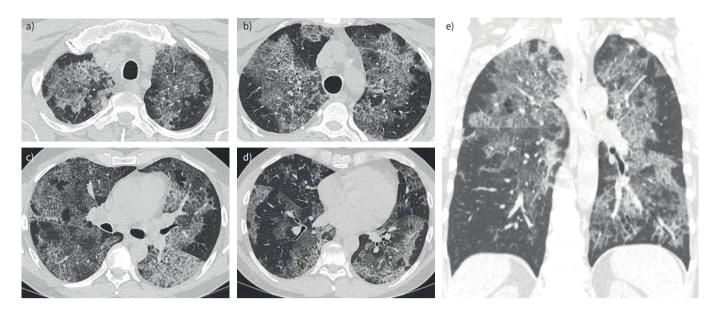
Computed tomography of the chest showing the radiographic findings in autoimmune pulmonary alveolar proteinosis in a 40-year-old man. Panels (a-d) show cross-sectional chest computed tomography (CT) images with ground glass opacification involving some but not all secondary lobules resulting in a distinctive "geographic" pattern. The distinctive pattern of interlobular septal thickening superimposed on ground glass opacification, often referred to as "crazy paving", is also demonstrated. There is relative sparing of the lower lobes of the lung. Panel e) shows a sagittal CT chest image of ground glass opacification in a patchy distribution with relative sparing of subpleural space and the costophrenic angles.
